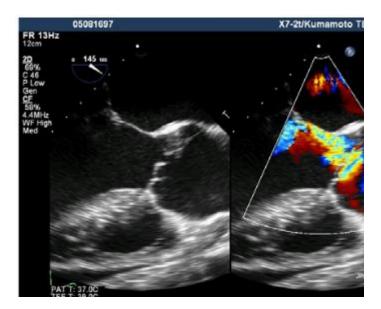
Transesophageal echocardiogram demonstrating prolapse of the right and left coronary cusps with no flap in the ascendingaorta
